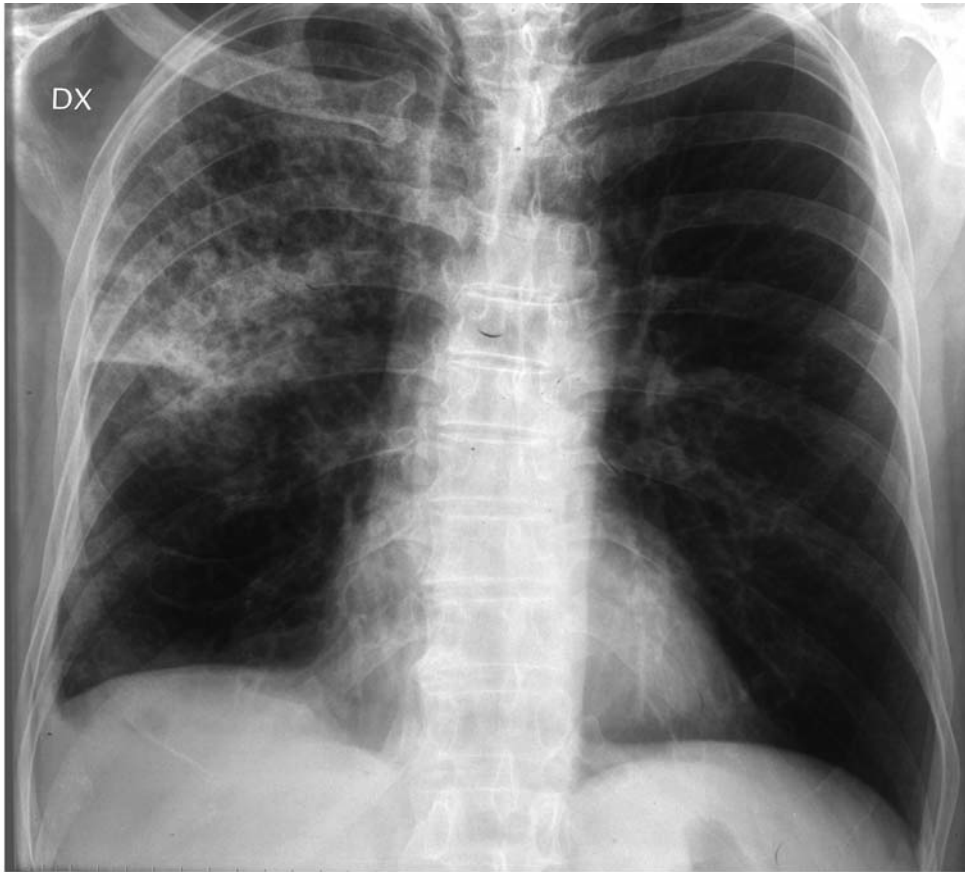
Parenchymal consolidation in the right upper lobe and opacities in the right lower lobe at baseline chest X-ray.
